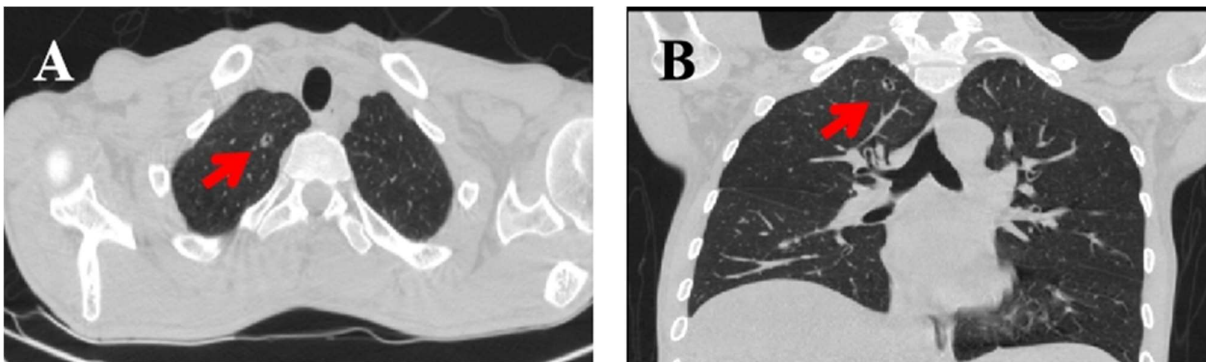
Chest CT of an existing small nodule in the right upper lung in the patient with HCC, which may be latent *M. kansasii* infection and finally developed pulmonary *M. kansasii* disease following
